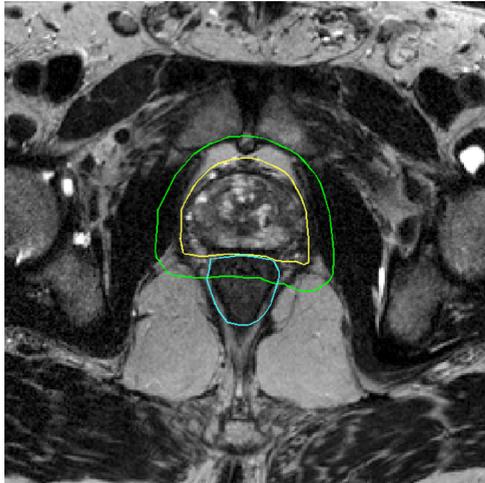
Delineation of the clinical target volume (yellow), planning target volume (green) and the rectum (blue) on a transversal T2-weighted magnetic resonance image.
